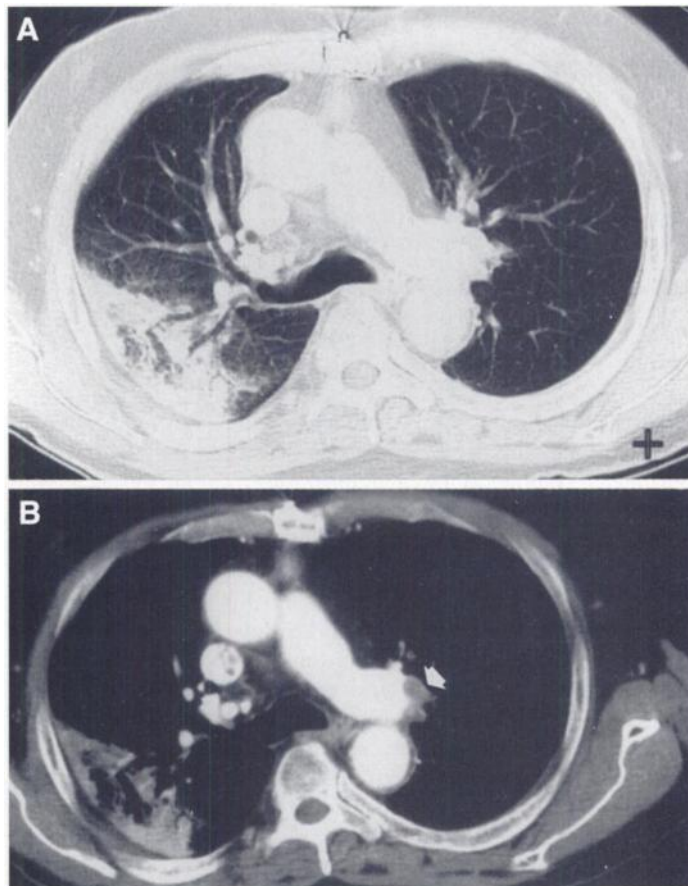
(A) CT scan obtained before antibiotic therapy at the level of the right mainstem bronchus shows focal area of consolidation in the posterior segment of the upper right lobe consistent with pneumonic process and (B) left hilar mass (arrow).
